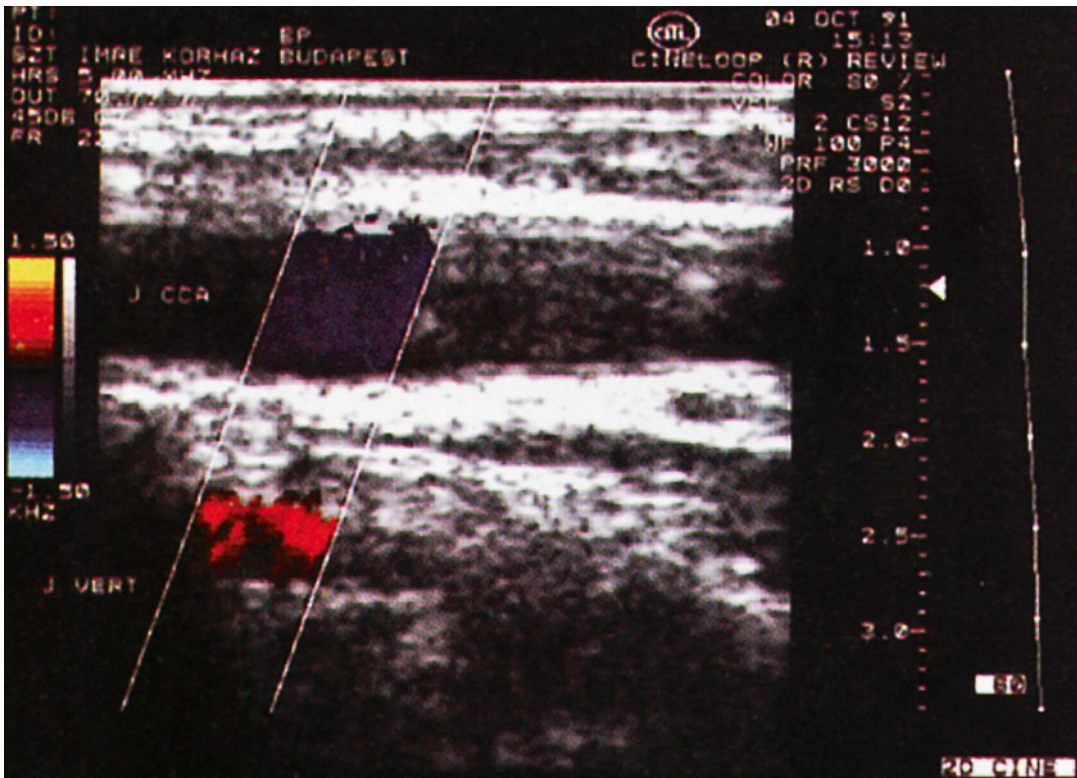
The color Doppler technique shows that the flow in the right vertebral artery (R VERT) is in the opposite direction to the flow in the common carotid artery (R CCA) characteristic of subclavian steal syndrome
